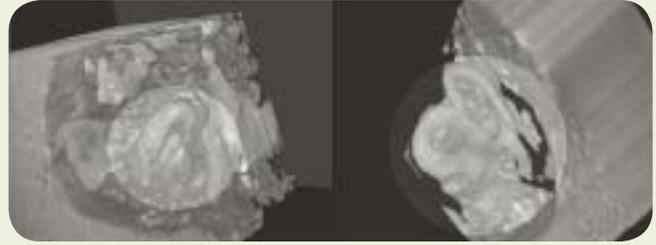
High Field Strength MRI
